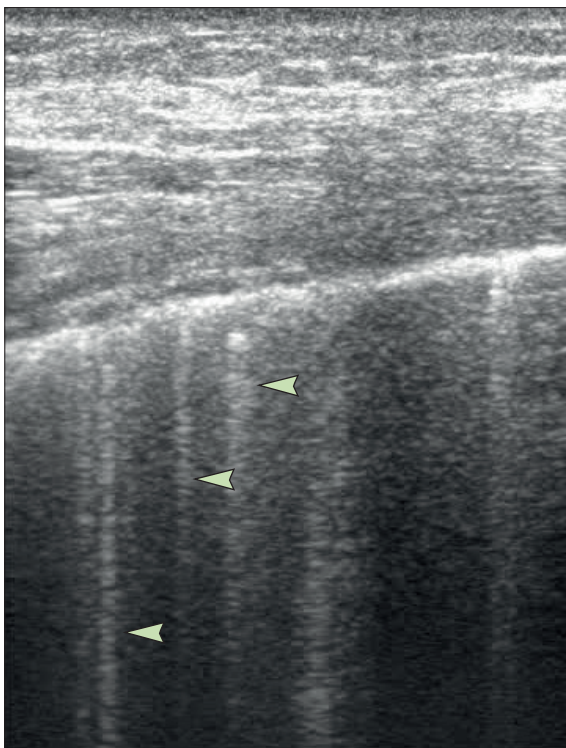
Lung ultrasound image showing B lines
